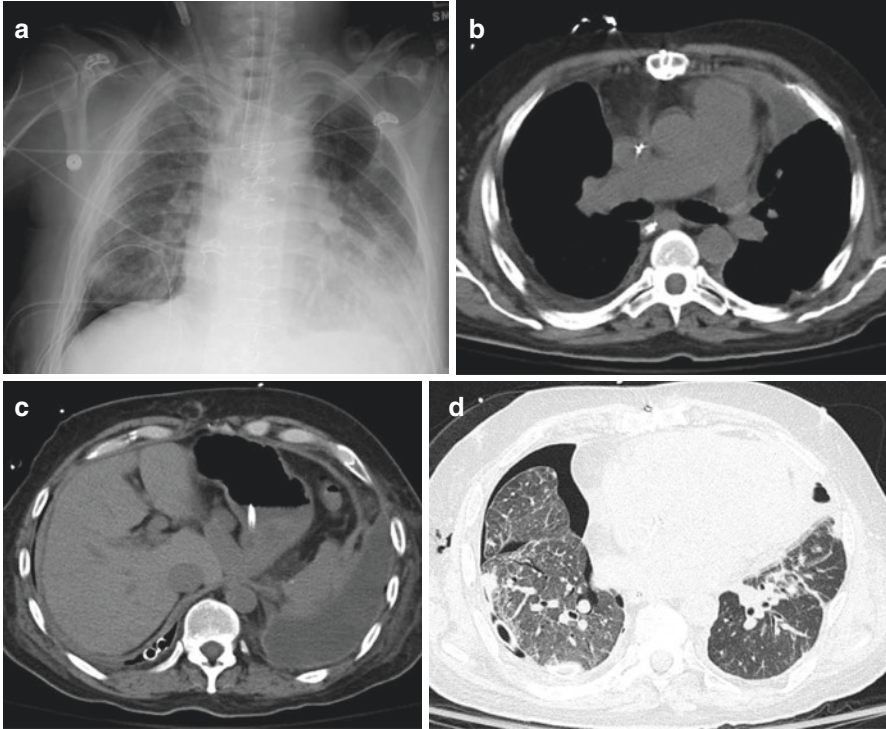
(a–d) A 47-year-old male is status post bilateral lung transplant with pleural complications identified bilaterally as seen on chest radiography (a) and axial CT images (b–d). There is a multiloculated complex left-sided pleural effusion with associated pleural thickening that was found to represent an empyema and a moderate-sized right-sided pneumothorax that required chest tube placement
